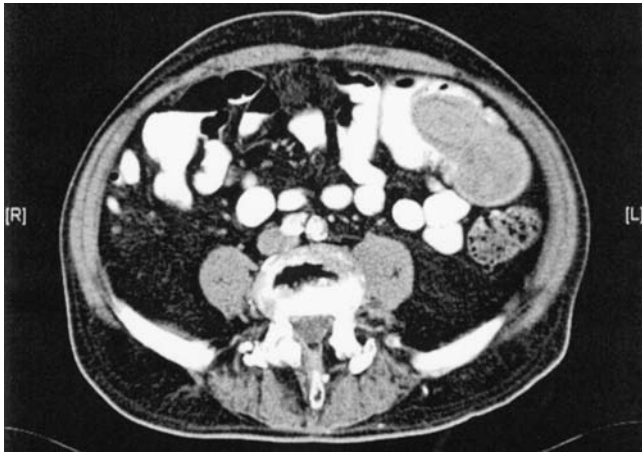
CT image of an ileal adenocarcinoma, obvious as a mass in the left midabdomen.
